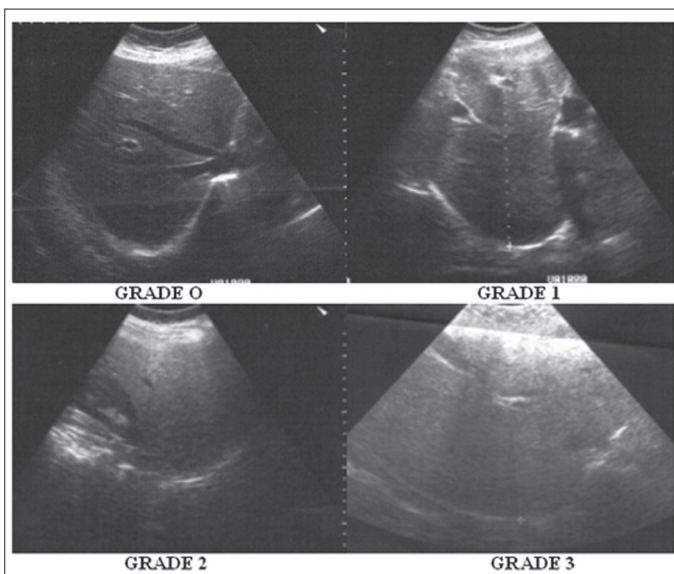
Ultrasonographic fatty liver stages (in 4 different patients). Grade 0- no fatty liver, Grade 1- mild fatty liver, Grade 2- moderate fatty liver, Grade 3- severe fatty liver
